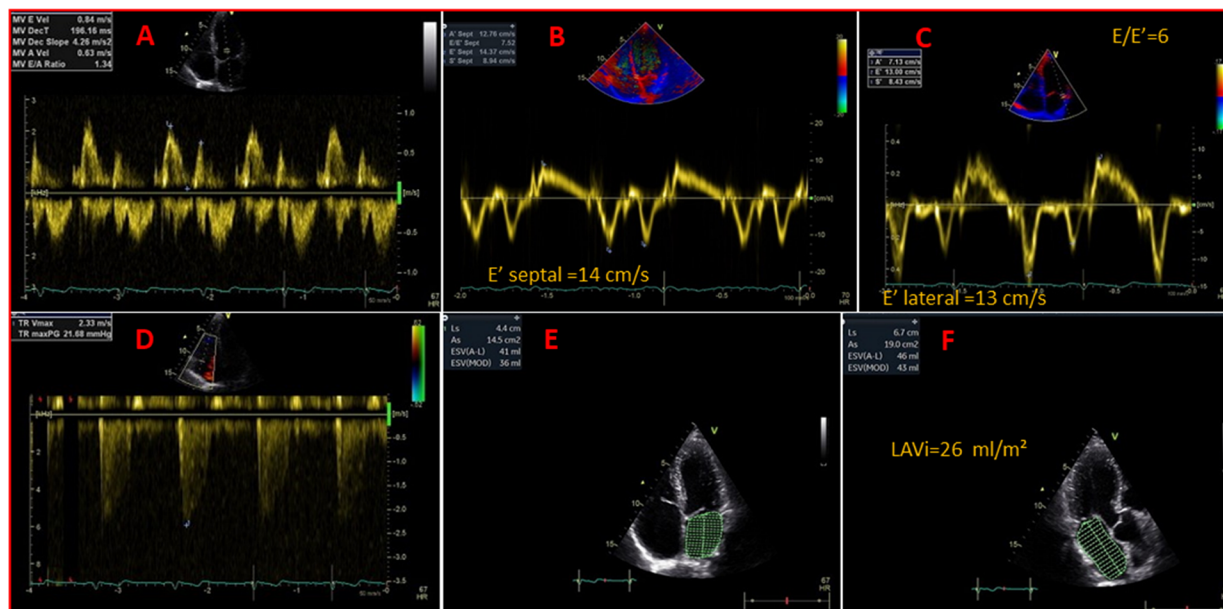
Normal diastolic function according to the current European guidelines. (A) Trans-mitral E velocity of 0.84 m/s and (B, C) tissue Doppler velocities of E' septal of 14 cm (B) and E' lateral of 13 cm/s (C), yielding an E/E' ratio of 6.2. (D) The peak velocity of tricuspid regurgitant jet (TR Vmax) of 2.3 m/s and (E, F) left atrial index (LAVi) of 26 mL/m², which are all normal.
